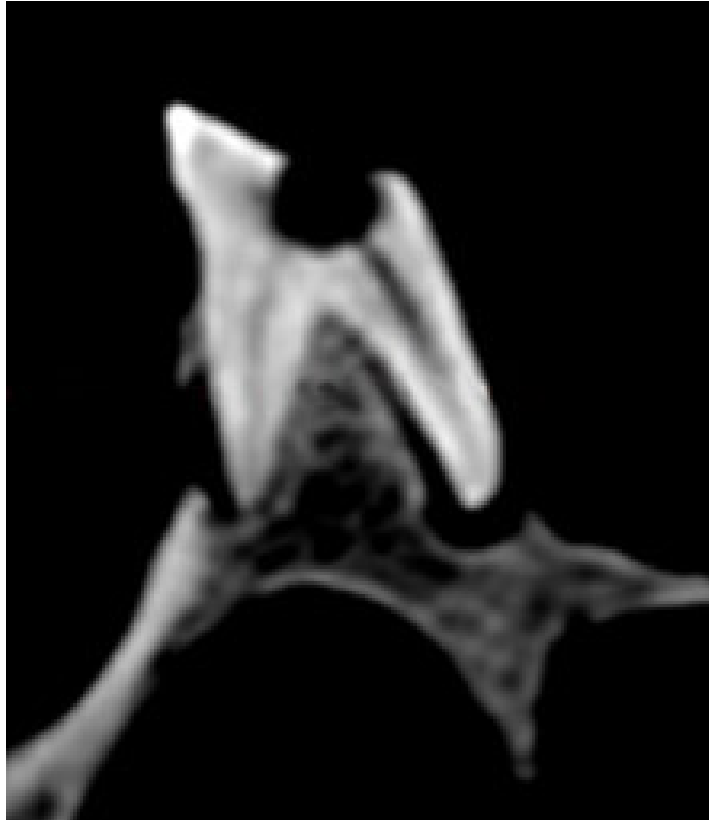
DVT image of the left first molar (M26): periapical reactions with openings to the palatal and buccal side of the alveolar bone.
